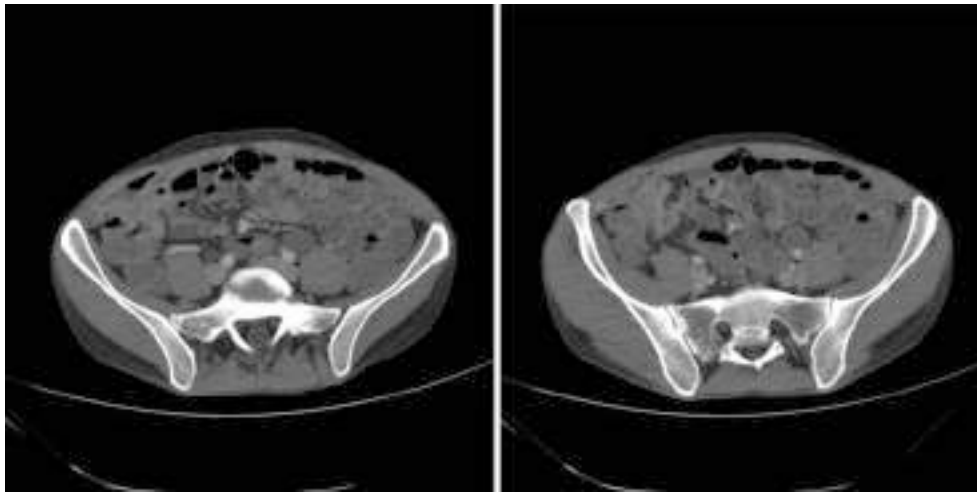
CT scan in a patient with Crohn's disease demonstrating fluid-filled bowel loops, thickened terminal ileum, and a subcutaneous right lower quadrant abscess.
